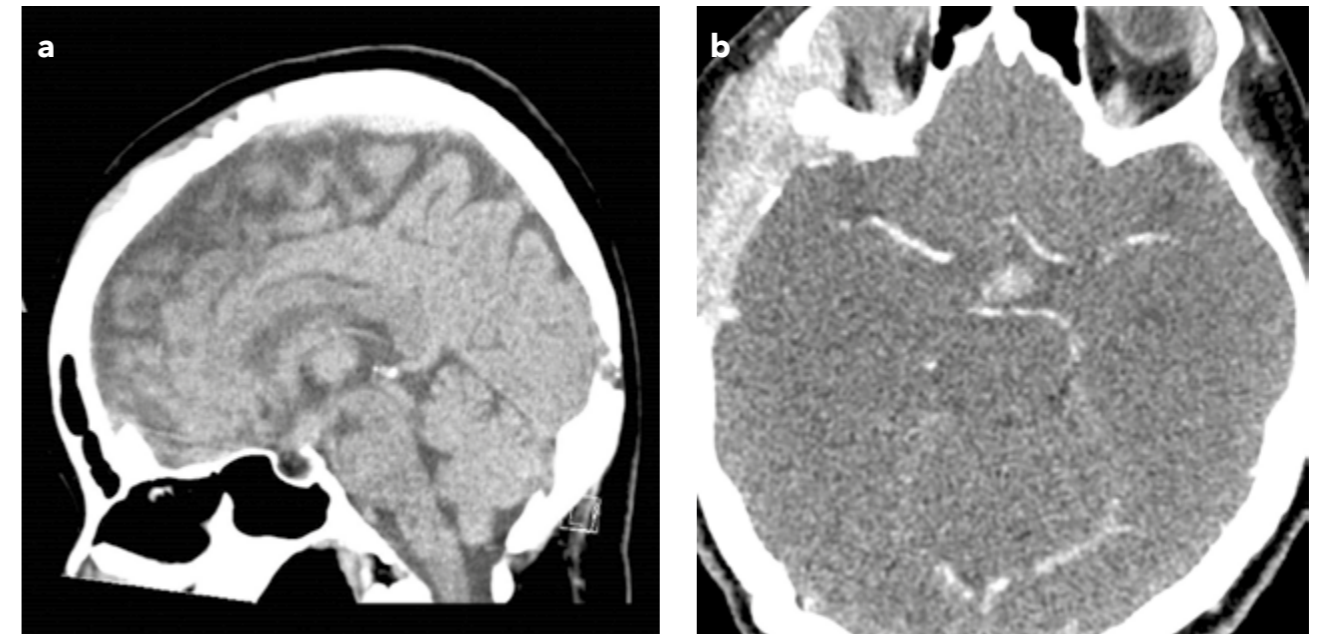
(a) Sagittal reconstruction of the non-contrast CT brain. (b) Axial contrast-enhanced CT brain.
